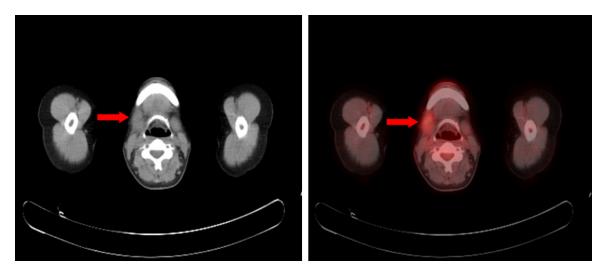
PET-CT showed a suspicious right submandibular lymph node (arrow) of 19 mm in diameter, with the MAX SUV 3.1.
